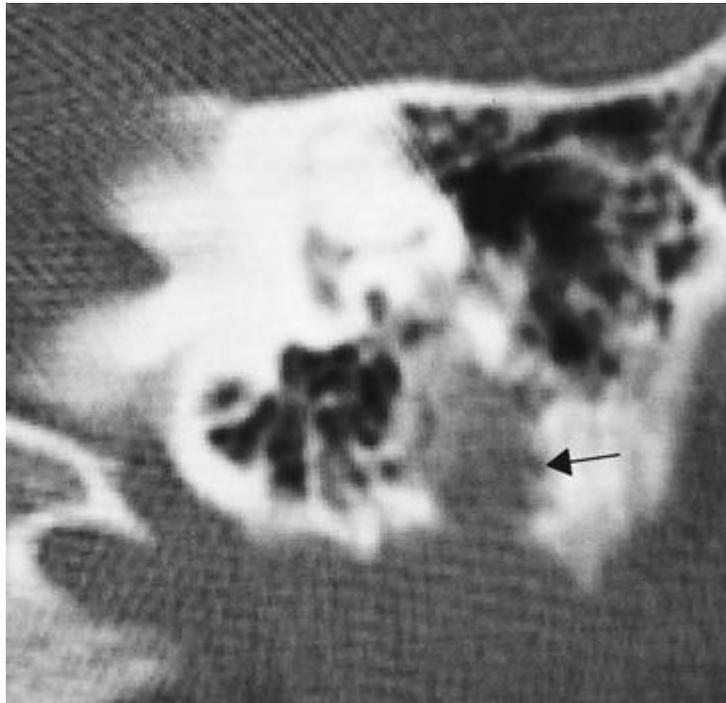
CT scan showing fallopian canal expanded and its irregular bony margins (Arrowed)
